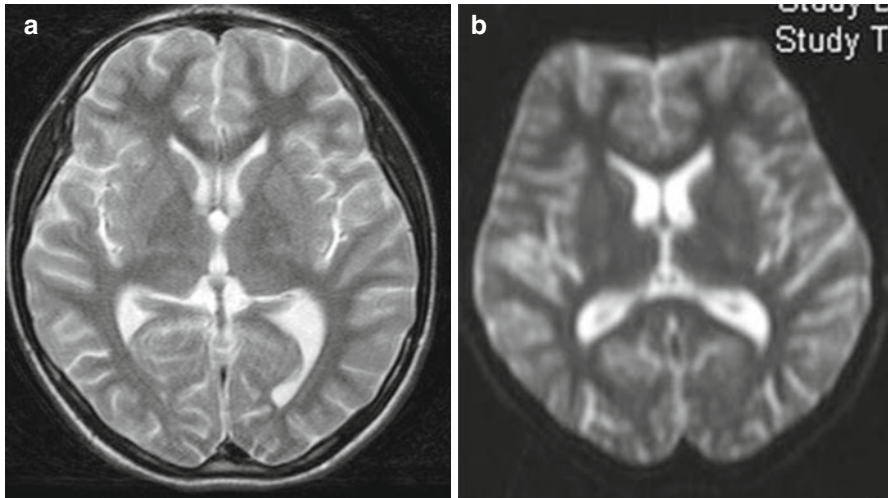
MRI in a teenager who had attempted hanging 6 days previously. (a) The T2-weighted images show high signal in the posterior putamen, globus pallidus, thalami, and hippocampi which were not obvious on a further T2-weighted image 2 weeks later. (b) The diffusion-weighted changes 6 days post-injury are more subtle. The patient apparently made a full recovery initially developed a severe dystonic quadriplegia 1 month after the hanging
